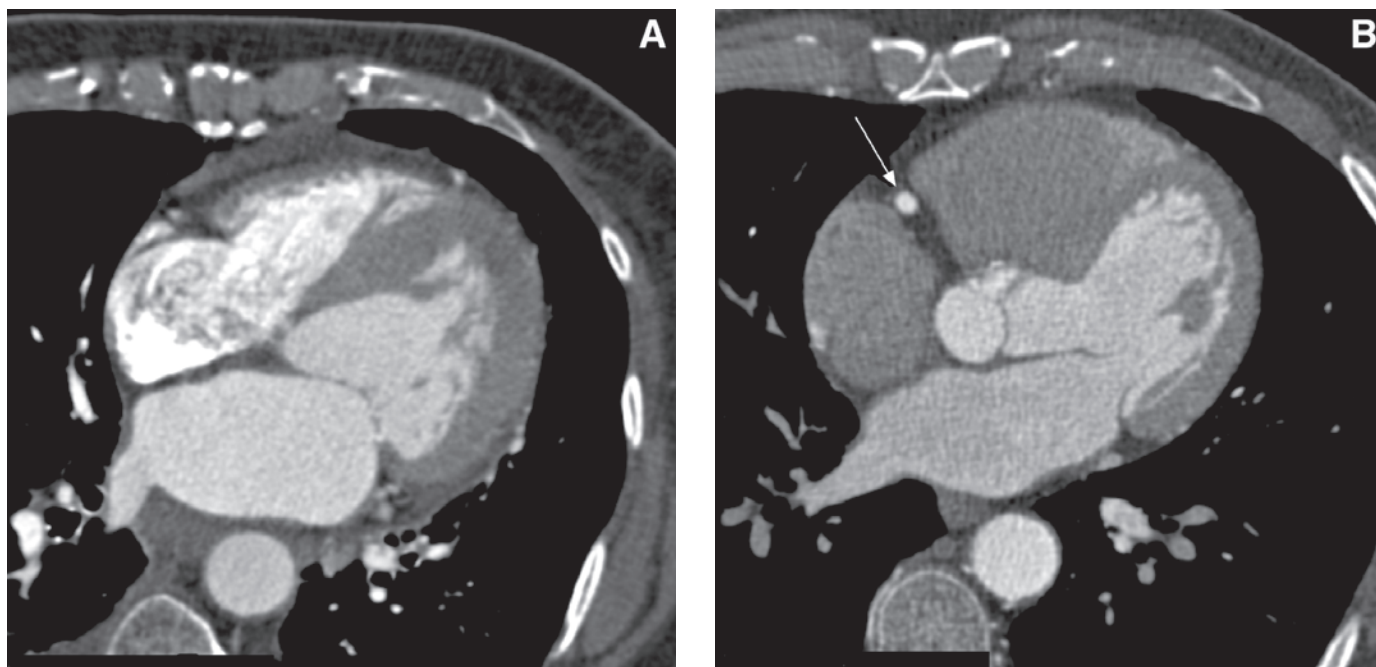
Axial multidetector-row CT (MDCT) image of a 4-row MDCT scanner system showing artifacts within the right atrium and ventricle due to contrast influx (A). By optimization of contrast application using 16-row MDCT these artifacts can be avoided, leading to a better depiction of the right coronary artery (arrow). However, for mass depiction, an enhancement of all cardiac chambers would be necessary.
